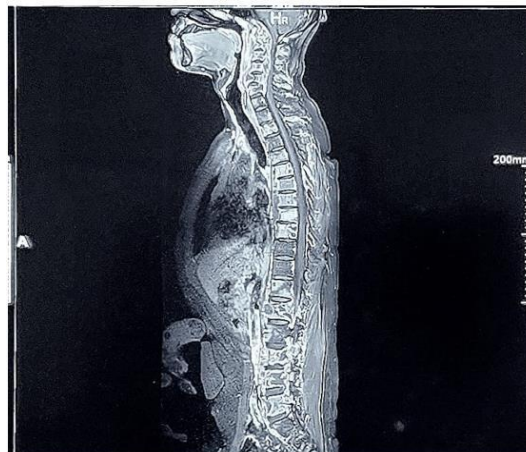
MRI WHOLE SPINE SHOWING : SKIPPED MULTIFOCAL EXTENSIVE SPINE TUBERCULOSIS
